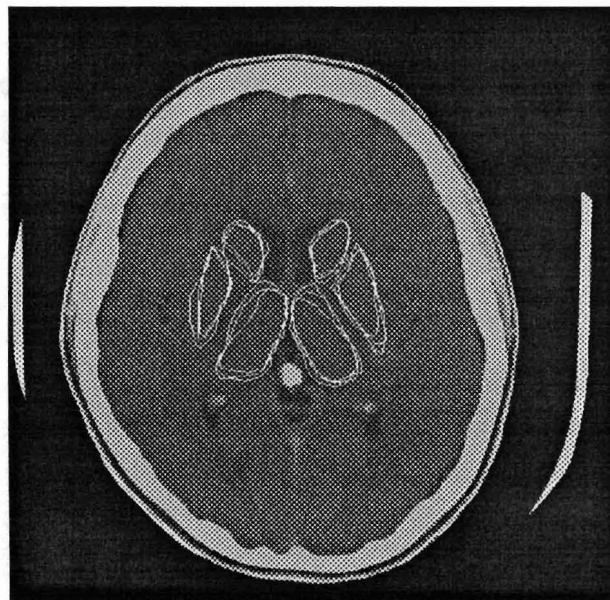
Typical example showing inter-observer variability. The three different experts' readings superimposed on the corresponding CT slice.
